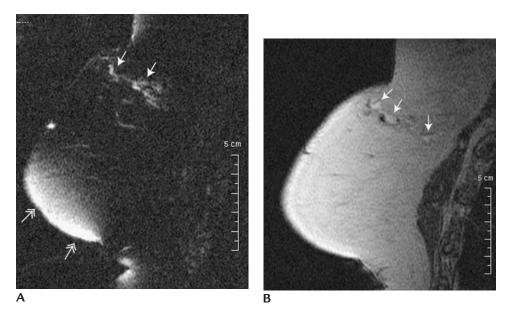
Subacute hematomas in patient following seat beat injury. (A) T2-weighted image with fat suppression demonstrating linear area of high signal intensity. Notice effect of suboptimal fat suppression inferiorly (*double headed arrows*). (B) T1-weighted image demonstrating linear areas of high signal intensity correlating with that seen on T2-weighted image. Patient with history of car accident and seat beat injury to right breast.
